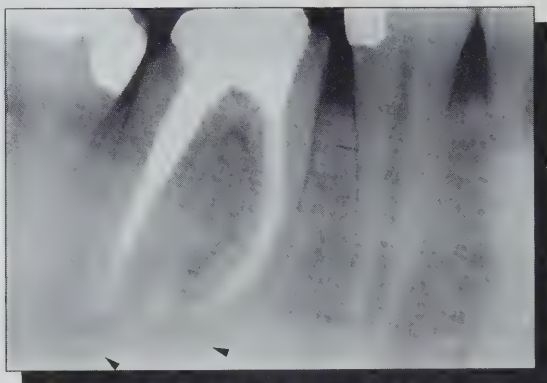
Pre-operative X-ray. Notice the lesions on each root.
